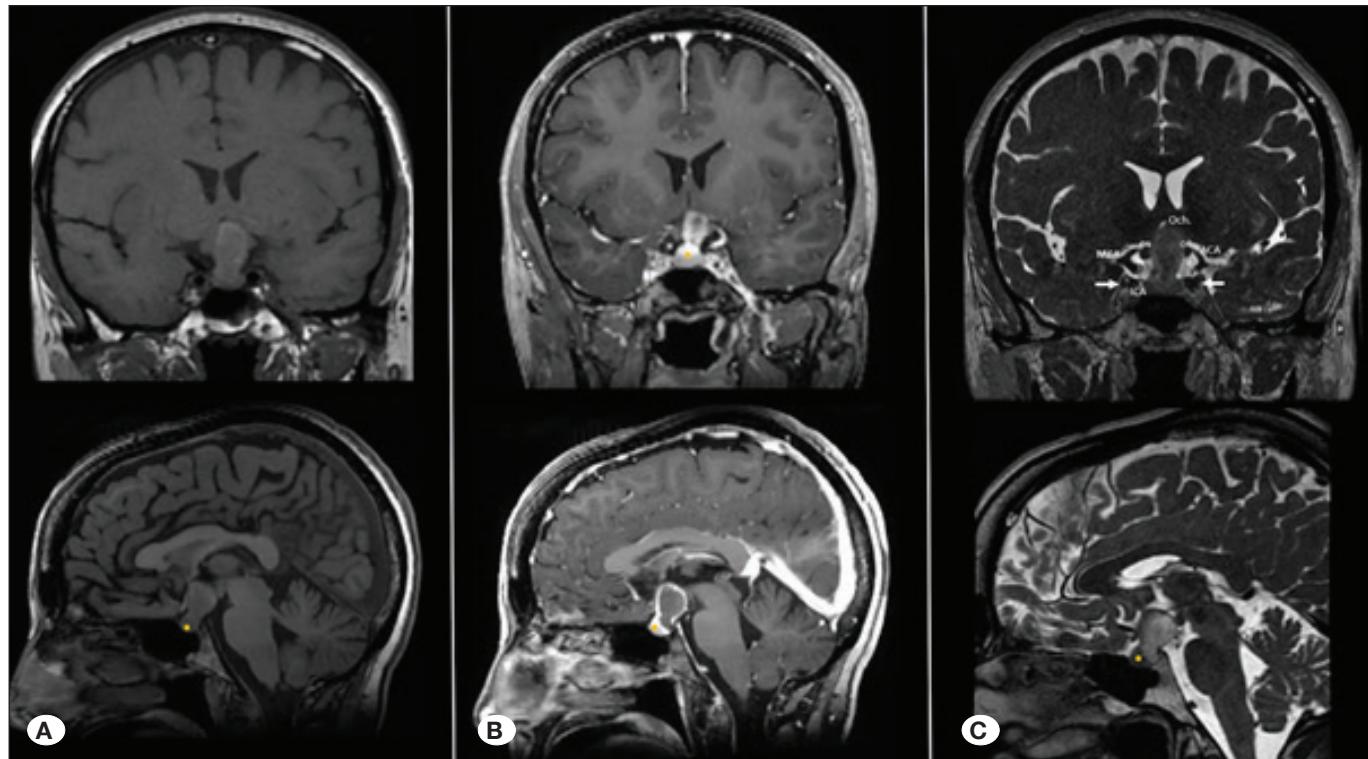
Preoperative T1 (A), T1 post-gadolinium (B), and T2-weighted (C) images showing a homogeneous, mild T1 spontaneously hyperintense, and T2 hypointense retro pituitary and infundibular lesion, with suprasellar extension and upward displacement (C) of the optic chiasm (Och.). Notice pituitary gland enhancement (yellow dot) and stalk thickening due to the lesion (B). Evidence of loss of posterior pituitary bright spot is observed on T1(A), sellar floor remains intact. In combination with clinical findings these images suggest presence of infundibulo-neurohypophysitis. ON: Optic nerve; ACA: Anterior cerebral artery; MCA: Middle cerebral artery; ICA: Internal carotid artery; White arrows: Oculomotor cistern and third cranial nerve (CN III).
